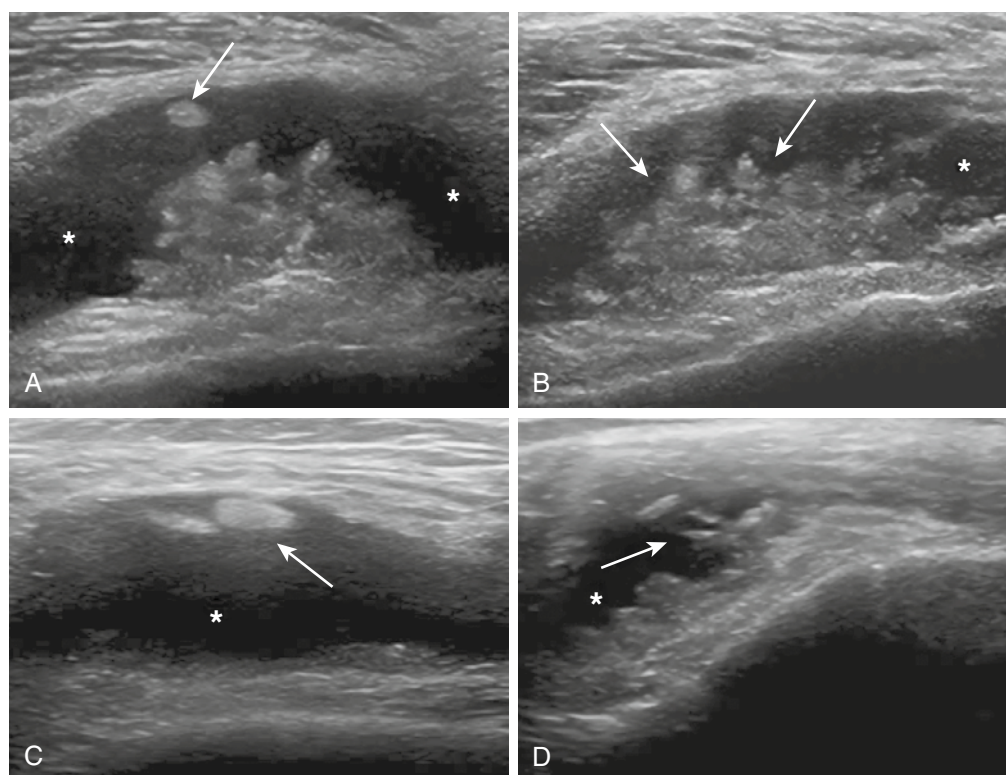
Ultrasound is used to assess the parapatellar recesses in the knee joint of a patient with osteoarthritis. A-D, The 12-MHz ultrasound images show various degrees of joint effusion (*stars*) and synovial proliferation (*arrows*), which assumes the aspect of polymorphous vegetations with characteristic polypoid or cauliflower-like morphology.
